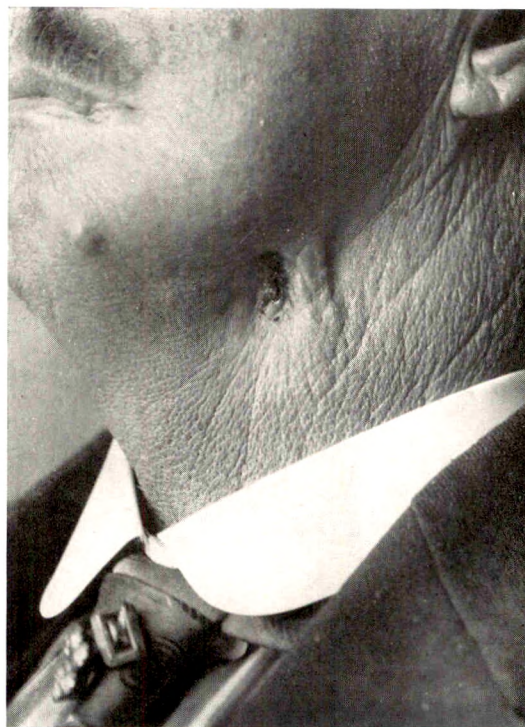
Same case as Figure 7, nine months after treatment by high power roentgen rays.
